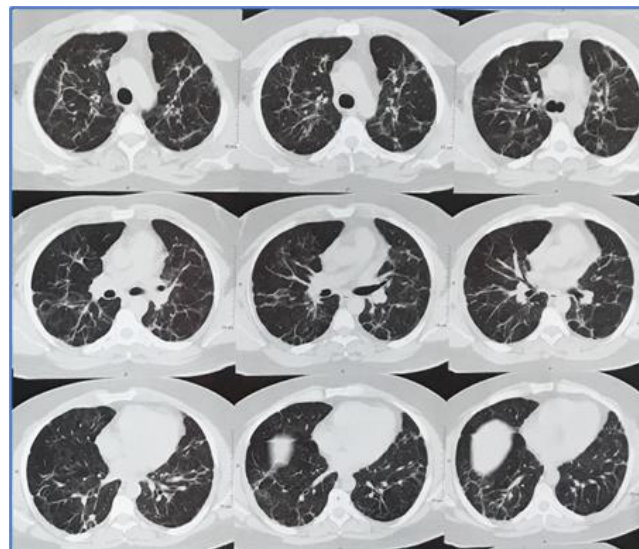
HRCT thorax showing minimal linear opacities and parenchymal bands in lower lobes on both sides
